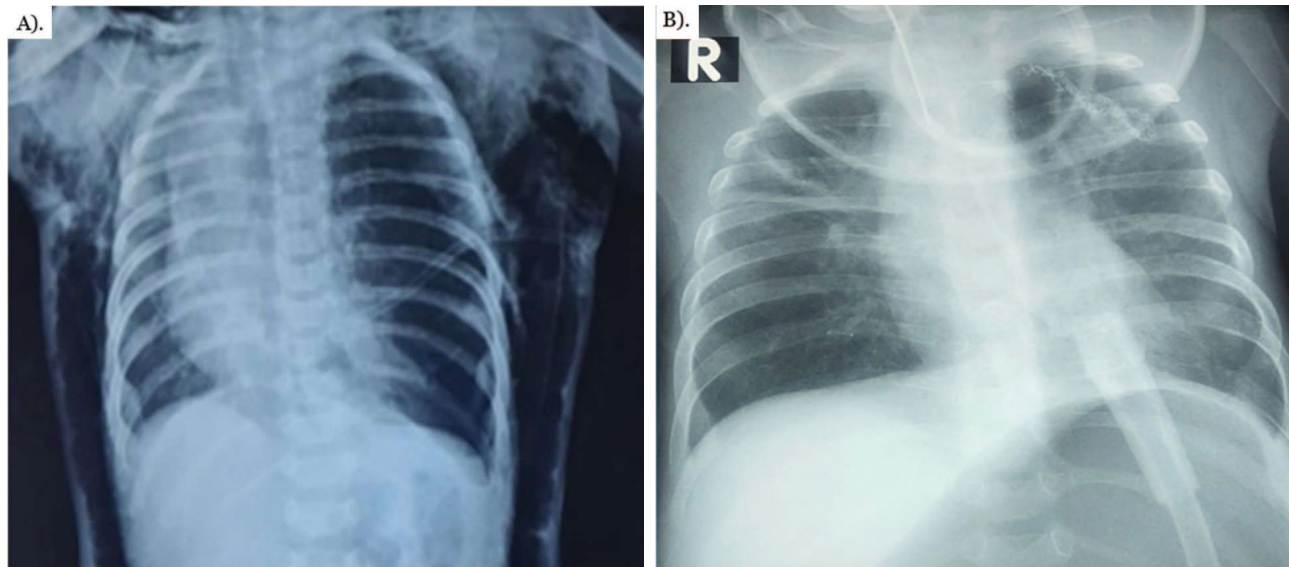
Radiological chest X-ray findings in a neonate with congenital lobar emphysema (CLE). (A) Preoperative chest X-ray showing hyperinflation of the left upper lobe with mediastinal shift to the right, consistent with typical CLE findings. (B) Postoperative chest X-ray following left upper lobectomy, demonstrating improved expansion of the contralateral lung and partial correction of mediastinal shift.
